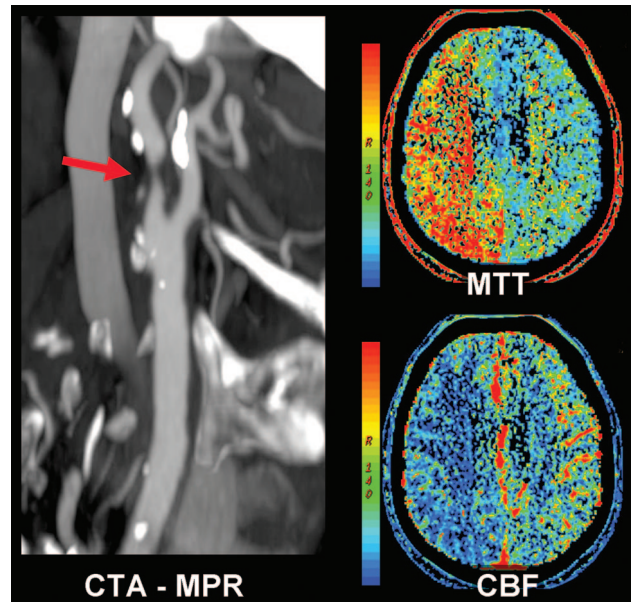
CTA and CT perfusion in severe internal carotid artery stenosis. Multiplanar reformations (MPR) show an 85% diameter stenosis and mural calcifications at the internal carotid artery origin (arrow), accompanied by severe prolongation in perfusion mean transit time (MTT) and reduction in cerebral blood flow (CBF).
